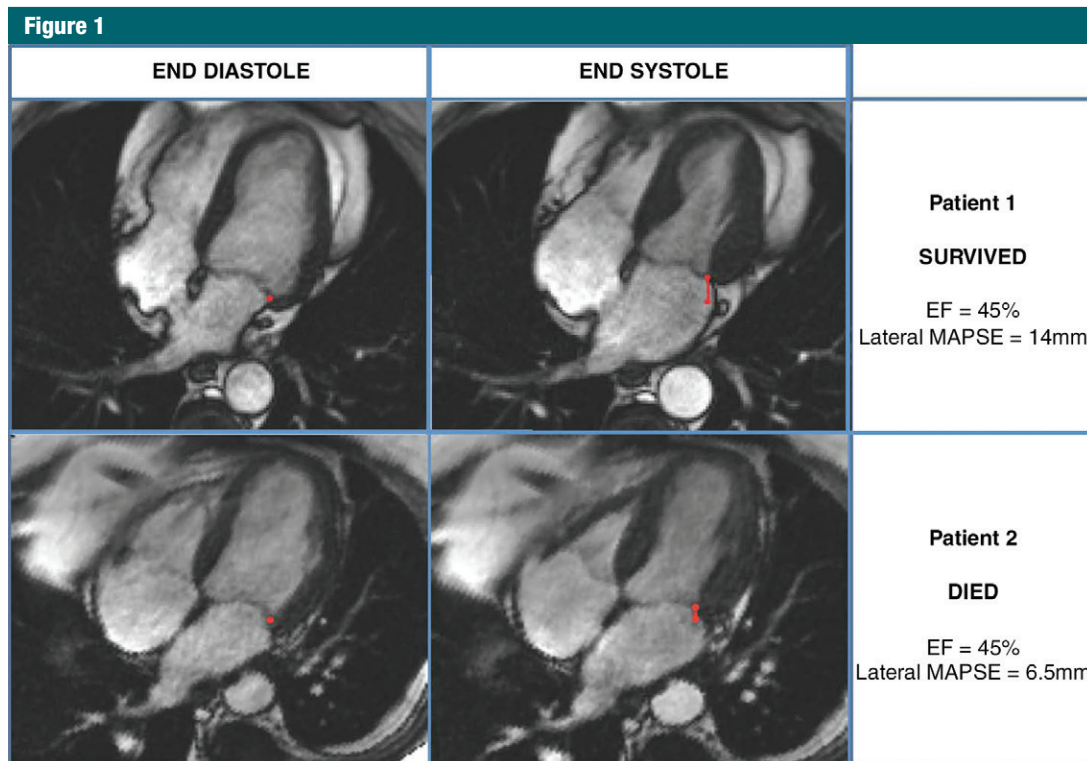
MR images demonstrate measurement of lateral MAPSE in a patient who survived (top) and a patient who subsequently died (bottom). Lateral mitral annular positions were recorded in four-chamber view at end diastole (images on left) and end systole (images on right), enabling measurement of lateral MAPSE (red line) in each patient.
